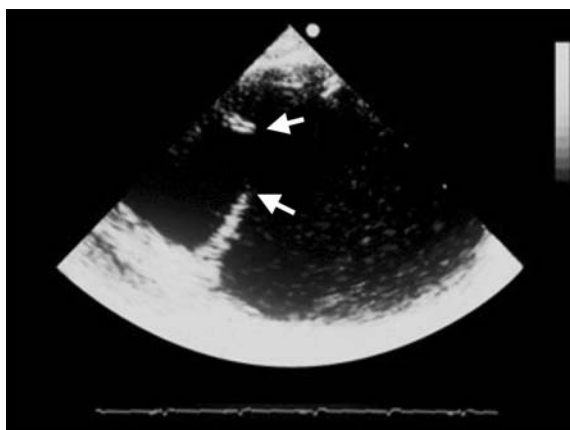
Transoesophageal echocardiography shows a large entry tear (greater than 10 mm) localised distally to the subclavian artery in type B dissection
